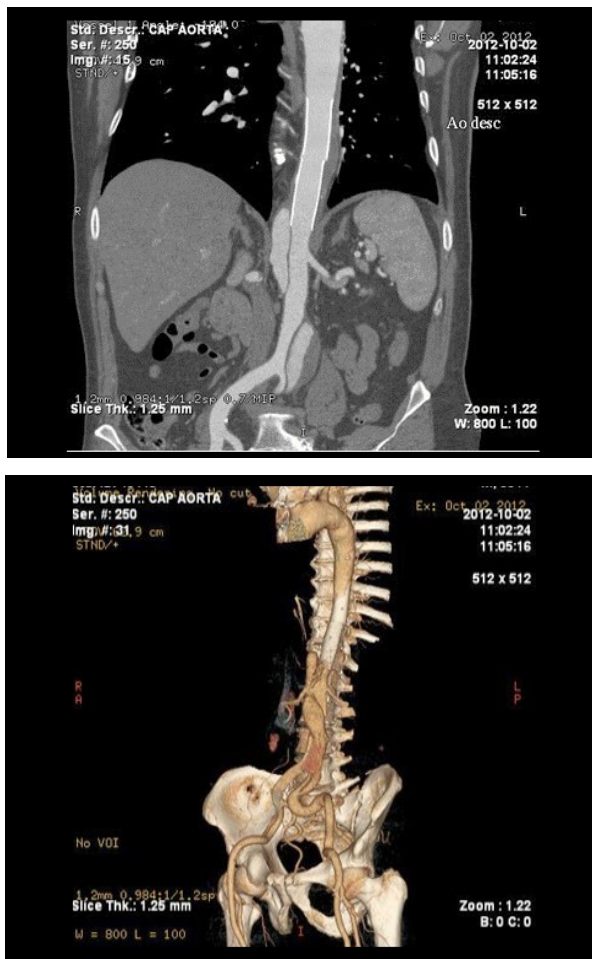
CTA 10 years later shows patent stents with complete expansion of true lumen and partial thrombosis of false lumen.
